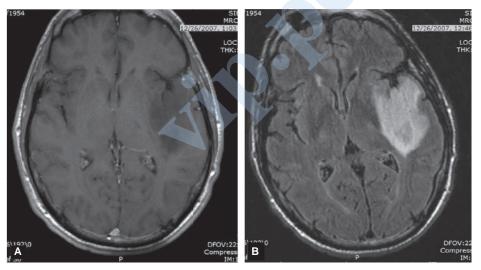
Axial MRI scan from a patient with a left temporal low-grade oligodendroglioma, showing no contrast enhancement on TI-weighted images (A) and diffuse hyperintensity on FLAIR images (B).
